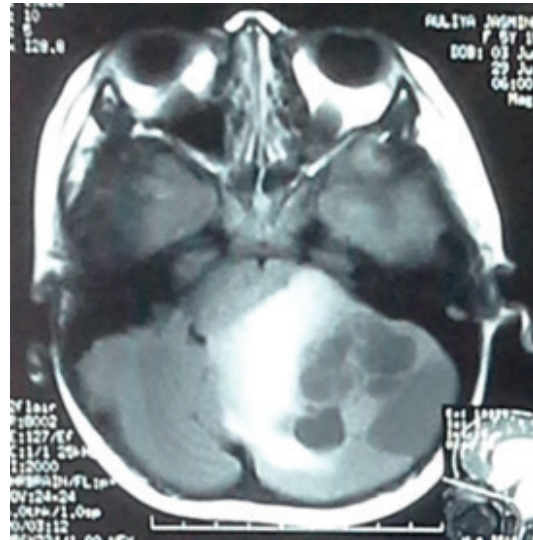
Head MRI showing pilocytic astrocytoma compressing the fourth ventricle and causing non-communicating hydrocephalus.
